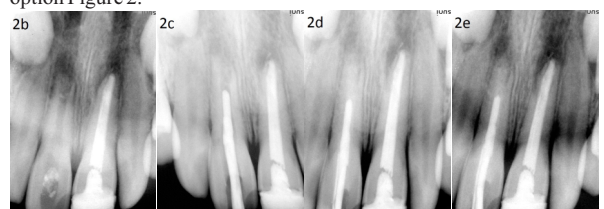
case 2. (2b) is a preoperative radiograph, (2c) checking the master cone, (2d) filling of Biodentine and obturation, (2e) follow up after 1 month
